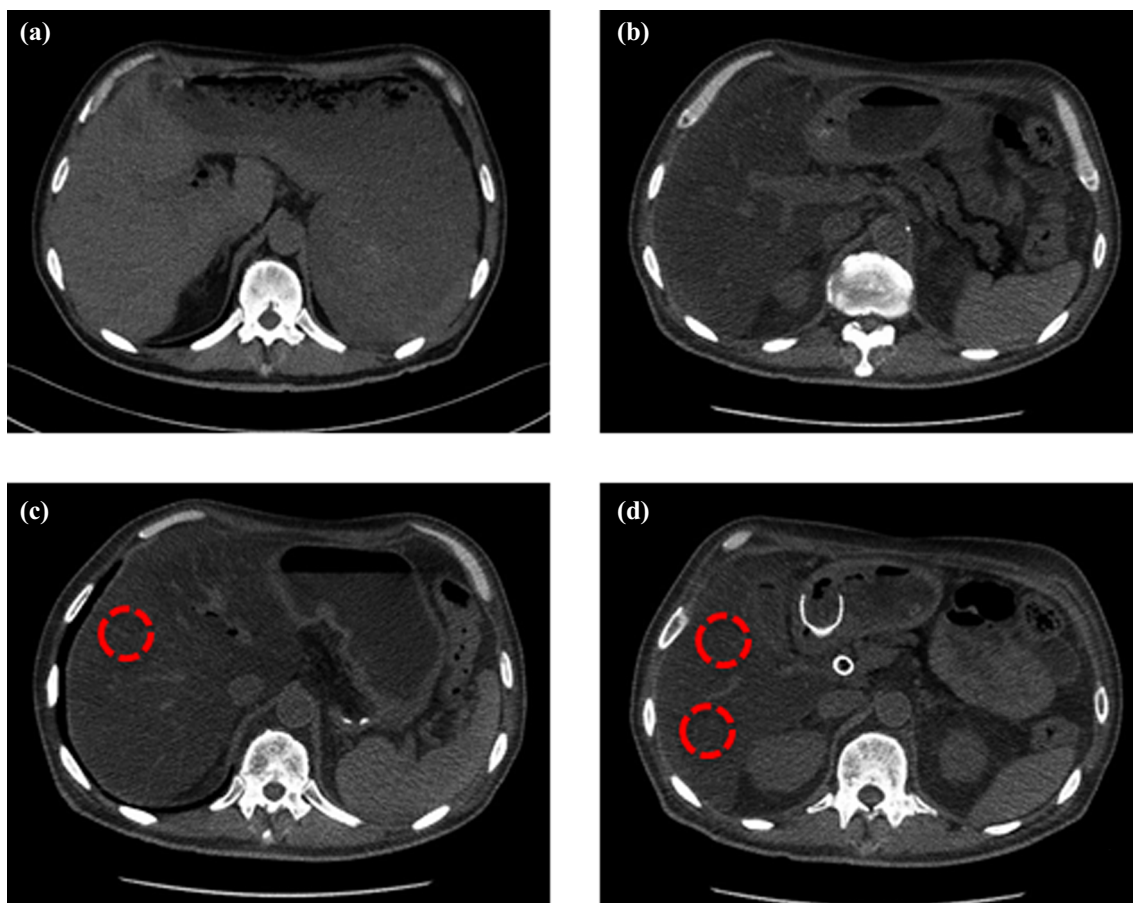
Axial unenhanced CT scans of the same patient with pancreatic adenocarcinoma before (a) and after (b, c and d) 3 months of neoadjuvant mFOLFIRINOX, demonstrating a dramatic change in the liver fat content, with appearance of severe steatosis (mean
